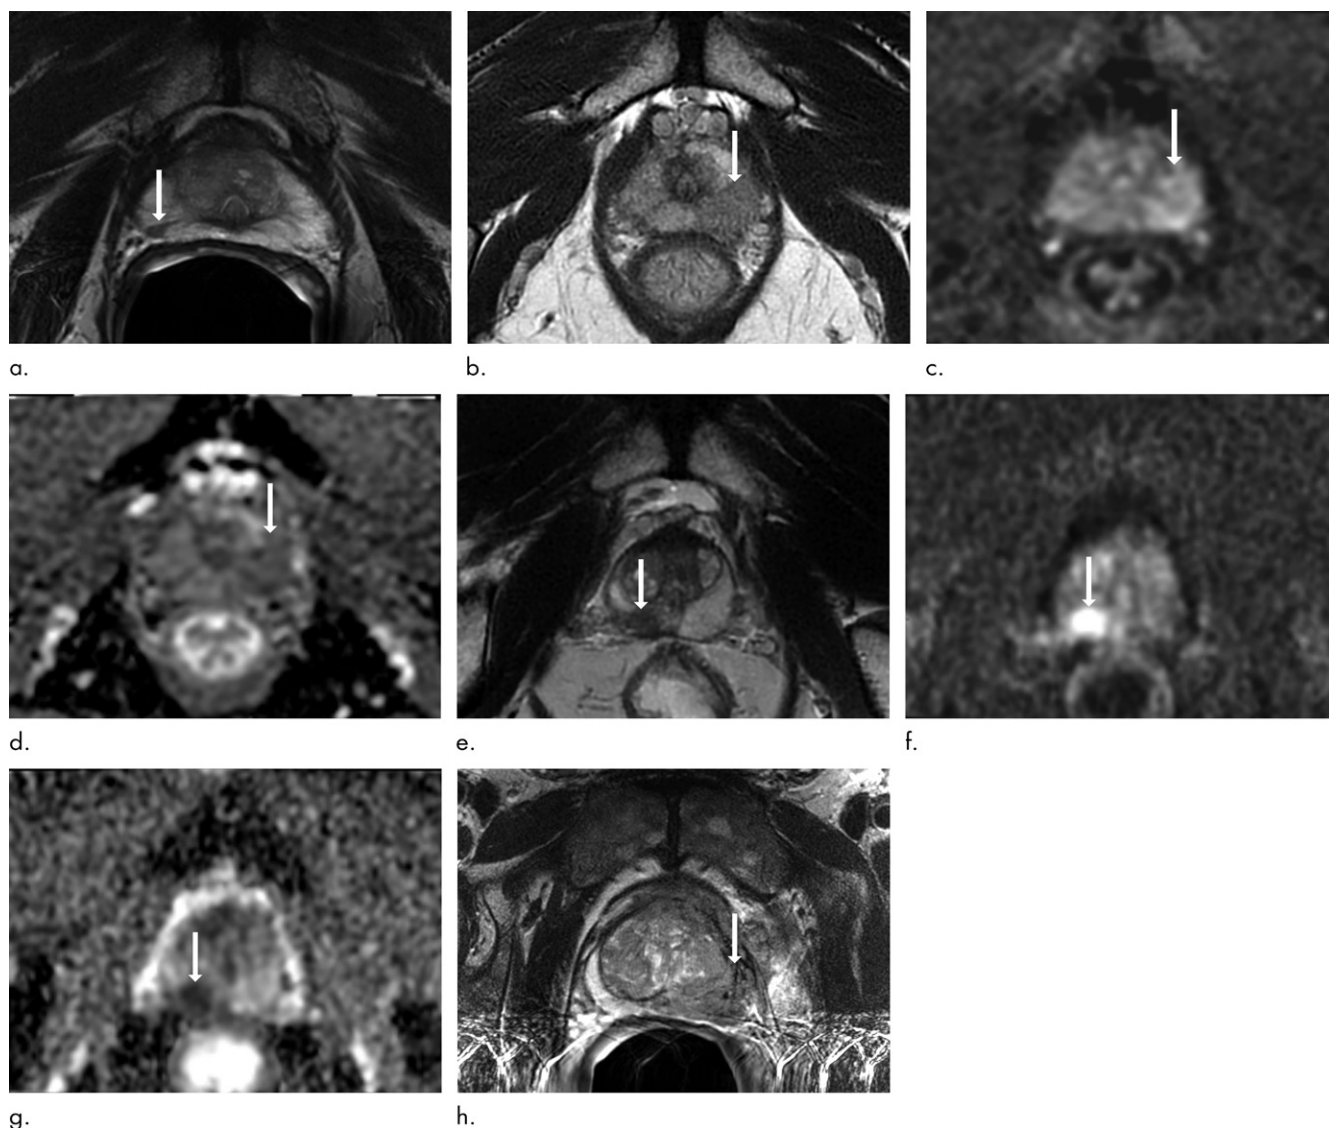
Images show representative peripheral zone lesions (arrow). (a) Prostate Imaging Reporting and Data System (PI-RADS) score 2. T2-weighted MRI scan shows triangular lesion with low T2 signal intensity in right midgland. (b-d) PI-RADS score 3. T2-weighted MRI scan (b), diffusion-weighted MRI scan obtained with high b value (c), and apparent diffusion coefficient (ADC) map (d) show focal lesion in left apex. Lesion has mildly low signal intensity on ADC map and mildly high signal intensity on diffusion-weighted image. No enhancement was seen on dynamic contrast material-enhanced image (not shown). (e-g) PI-RADS score 4. T2-weighted MRI scan (e), diffusion-weighted MRI scan obtained with high b value (f), and ADC map (g) show 1.0-cm focal lesion in right midgland. Lesion has markedly low signal intensity on ADC map and markedly high signal intensity on diffusion-weighted MRI scan. (h) PI-RADS score 5. T2-weighted MRI scan shows large left midgland lesion associated with extraprostatic extension.
